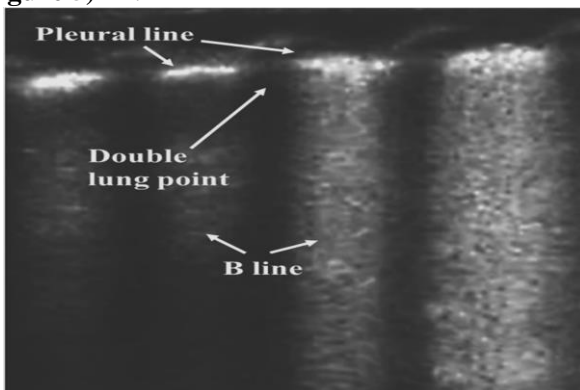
Transient tachypnea of the newborn on lung ultrasonography ^[21].
